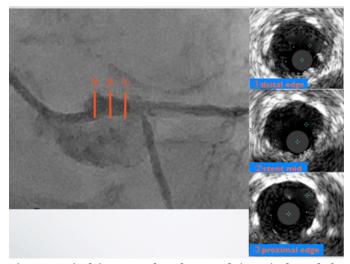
Final intravascular ultrasound (IVUS) showed the stent apposition.
